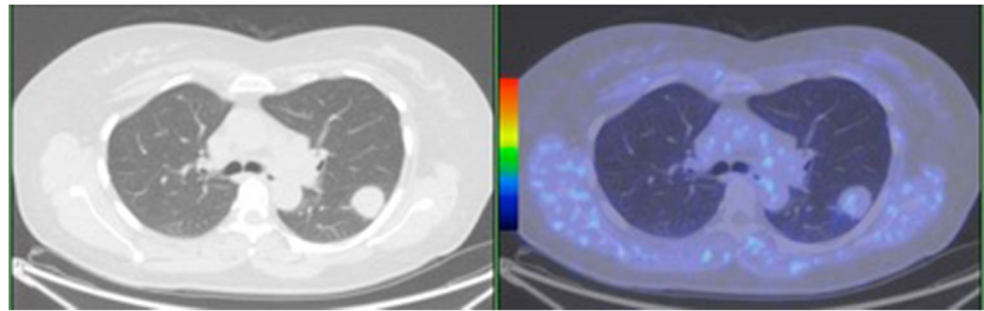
Female patient with clear cell RCC (pT3apN0). 18F-FAZA PET/CT did not show any tracer uptake nor in the right kidney neither in the left pulmonary nodule
